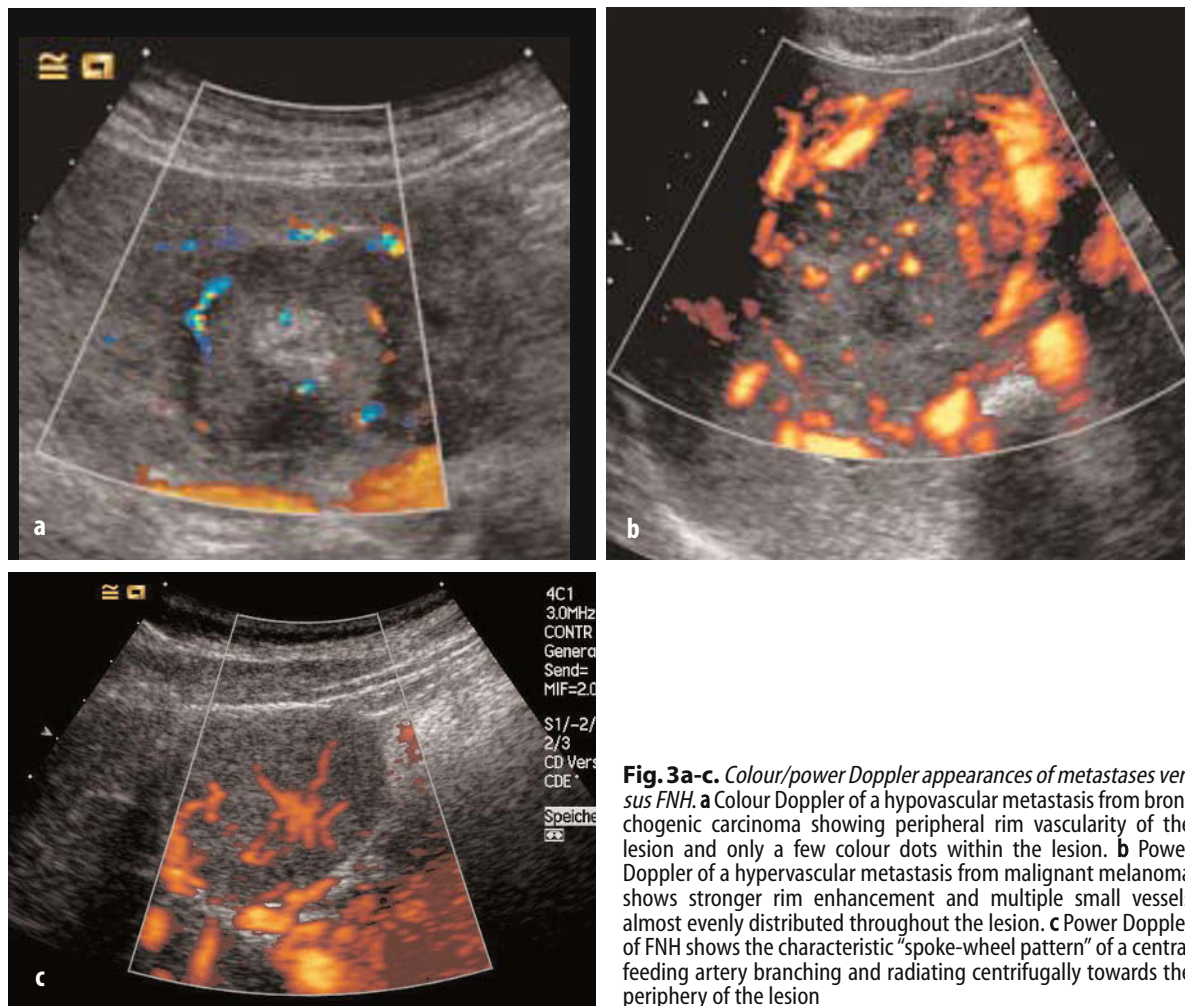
Colour/power Doppler appearances of metastases versus FNH. a Colour Doppler of a hypovascular metastasis from bronchogenic carcinoma showing peripheral rim vascularity of the lesion and only a few colour dots within the lesion. b Power Doppler of a hypervascular metastasis from malignant melanoma shows stronger rim enhancement and multiple small vessels almost evenly distributed throughout the lesion. c Power Doppler of FNH shows the characteristic “spoke-wheel pattern” of a central feeding artery branching and radiating centrifugally towards the periphery of the lesion
